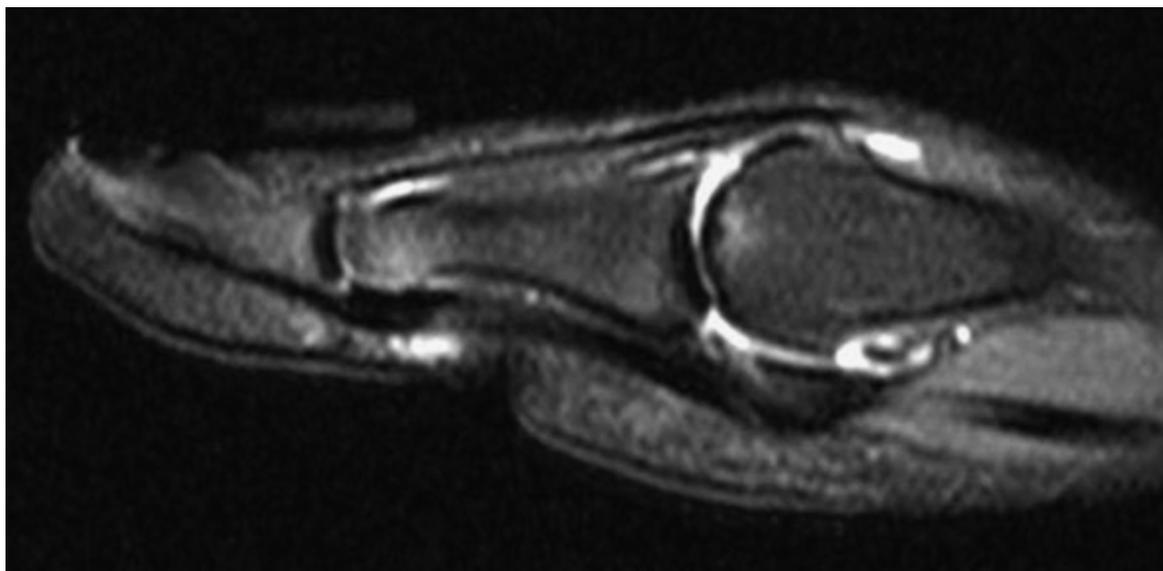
27 Magnetic resonance image of the first metatarsophalangeal joint may reveal osseous or articular cartilage abnormalities.
